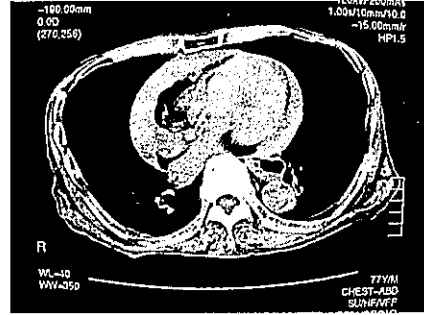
Autopsy imaging, CT, slice #20
